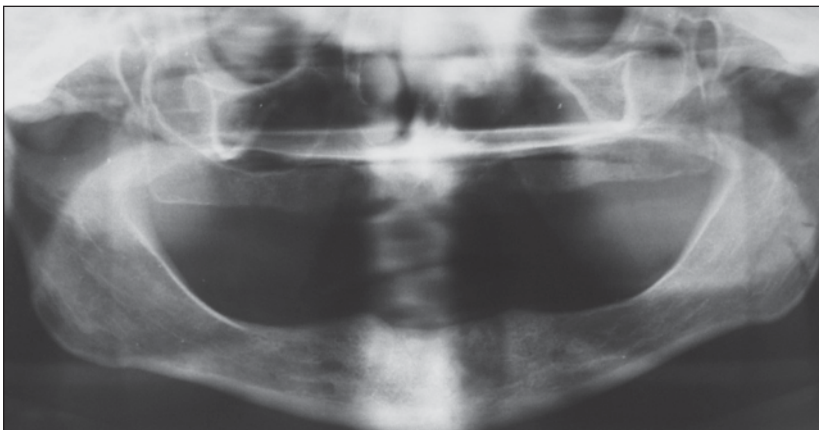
Panoramic radiograph 1 year after extraction of the implants.
